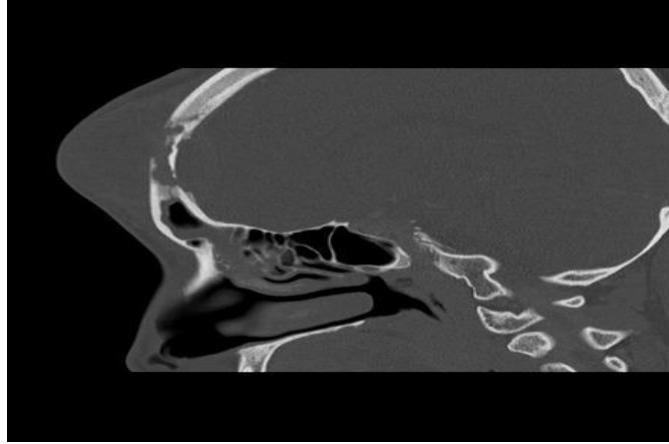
sagittal bone window CT image with Pott tumor in frontal sinuses
